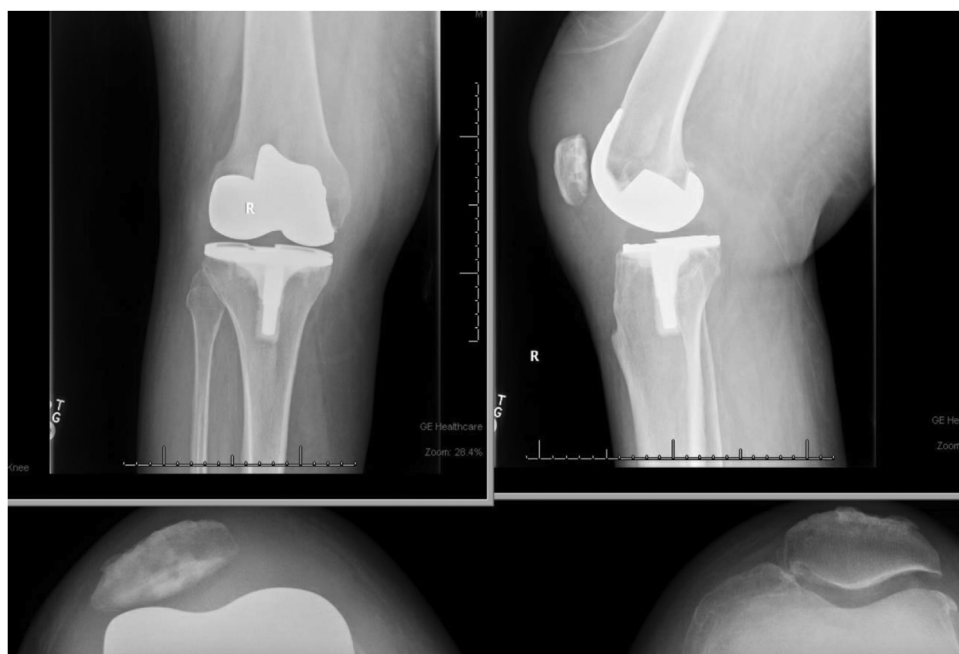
Post-TKA x-rays demonstrating a large joint effusion and lateral subluxation of the patella.
